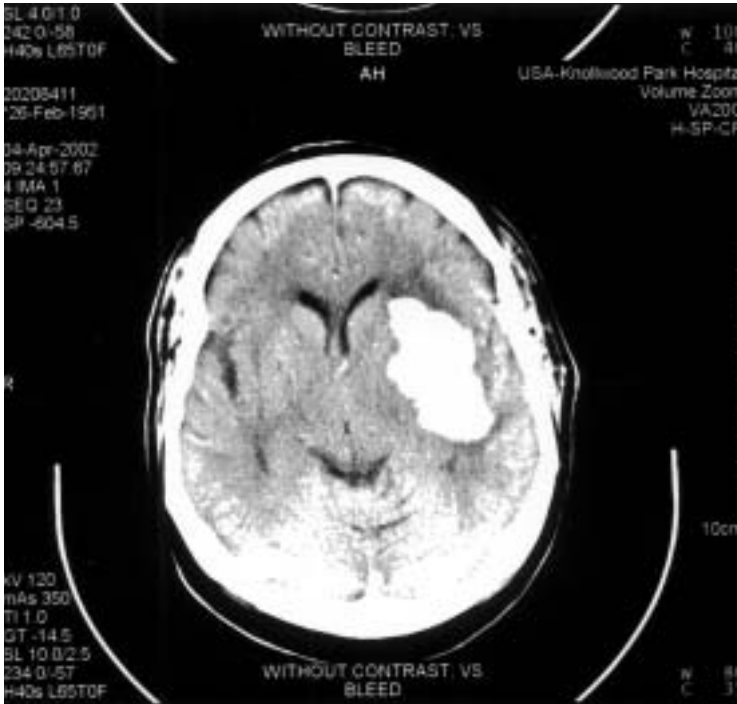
A brain CT scan performed without contrast dye shows an area of hemorrhage (bleeding) within the brain tissue of the left hemisphere. The patient had uncontrolled hypertension (high blood pressure).
